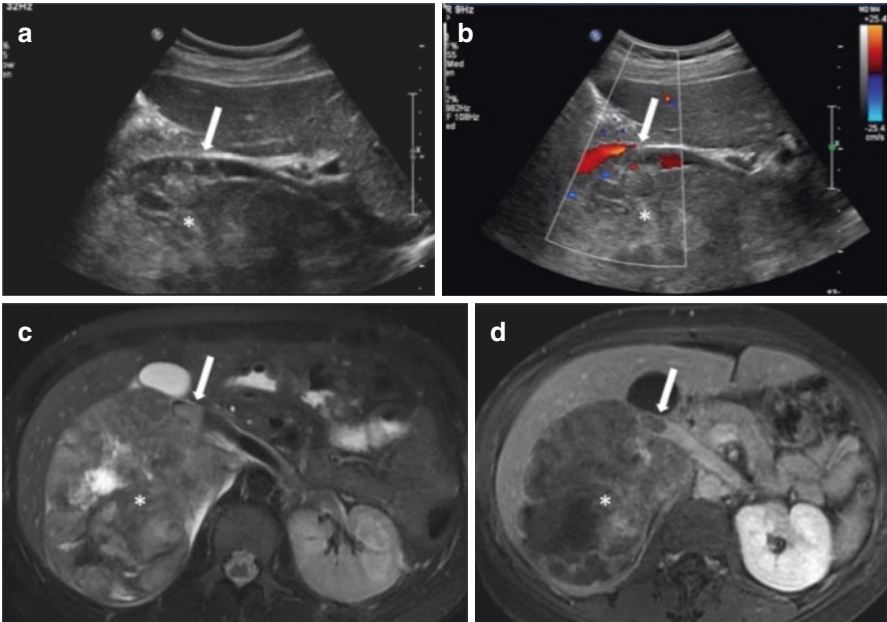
Right adrenal carcinoma. Large heterogeneous neoplastic lesion at the right adrenal gland region (*), hypoechoic on US (a), compressing the IVC on Doppler-US, with thrombus within the venous lumen (arrow on b). The mass shows heterogeneous signal intensity on T2WI (c) and enhancement on T1WI (d), with tumor thrombus in the right adrenal vein extending into the inferior vena cava (arrows)
